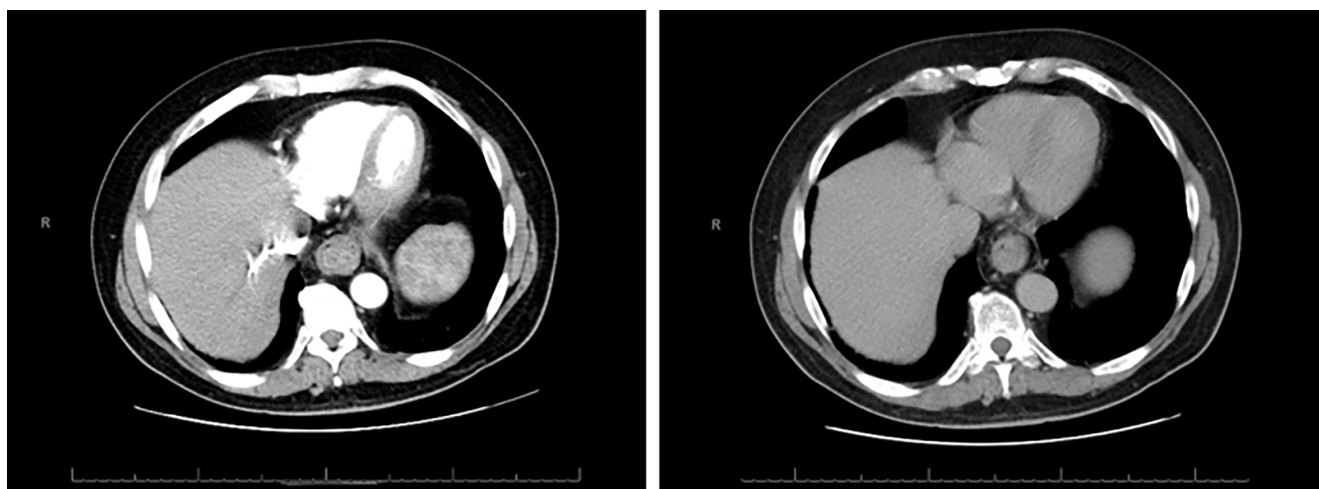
Computed tomography scan describing the esophageal lesion as a polyp and ruling out lesions suggestive of metastasis. Images property of the authors.
